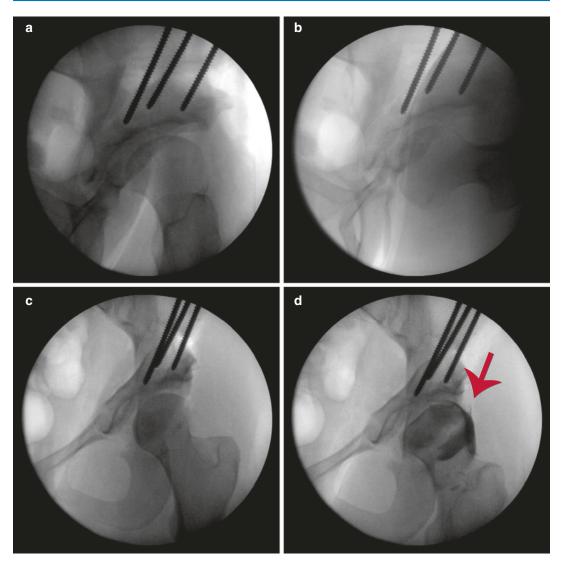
Periacetabular osteotomy (PAO) Correction: Once free, the acetabular fragment is repositioned to provide anterior coverage (a) that permits 90° of hip flexion (b). Additionally, (c) the fragment should be repositioned to provide significant lateral coverage as judged by an AP radiograph. (d) An arthrogram can help judge the position of the un-ossified cartilaginous epiphysis and position of the labrum
